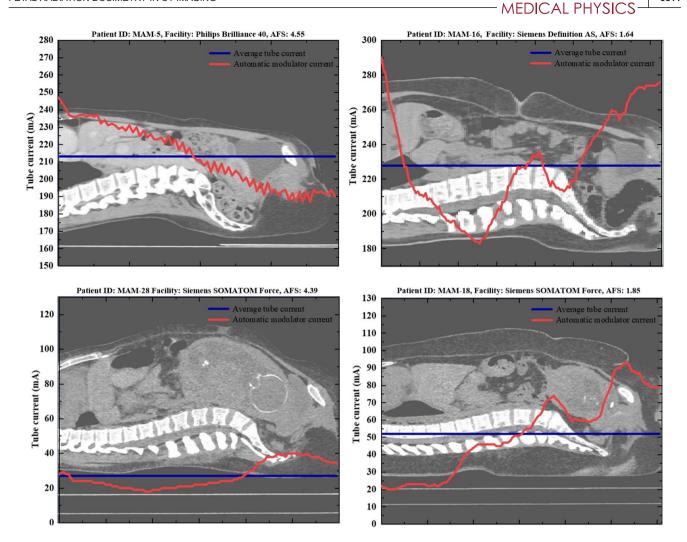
Automatic tube current modulation in real-world abdominal and pelvic CT examinations for the studied pregnant patients.
